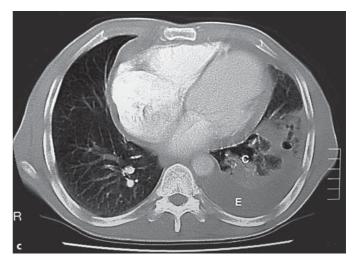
A series of images obtained from the same patient who presented with a complicated parapneumonic effusion. a The chest radiograph: note the inhomogeneous nature of the left-sided opacity, the absence of the associated costophrenic angle, and the apparent air lucencies within the opacity. b A thoracic US revealed a classic septated complicated parapneumonic effusion. Note the strands of echogenic material within the loculations. L = Loculations; S = septae. c A chest CT scan did not show any loculations within the pleural fluid collection. Note the underlying pulmonary consolidation that was not apparent on the chest radiograph. C = Consolidation; E = effusion.
